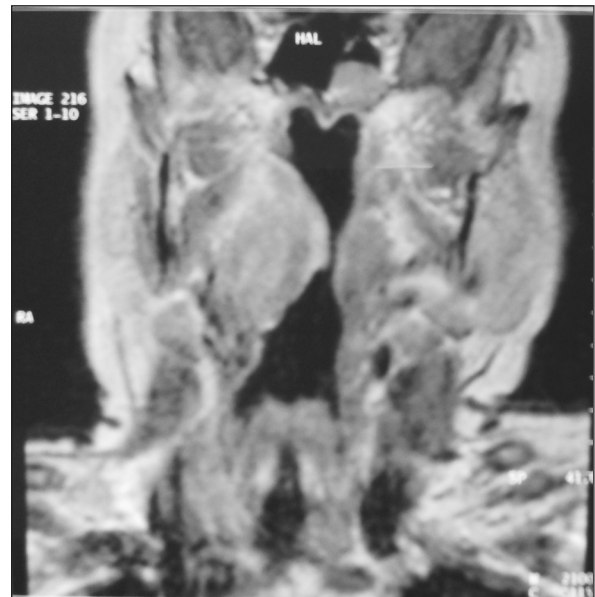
The coronal plane MR imaging showing oropharyngeal space narrowed by mass effect.
